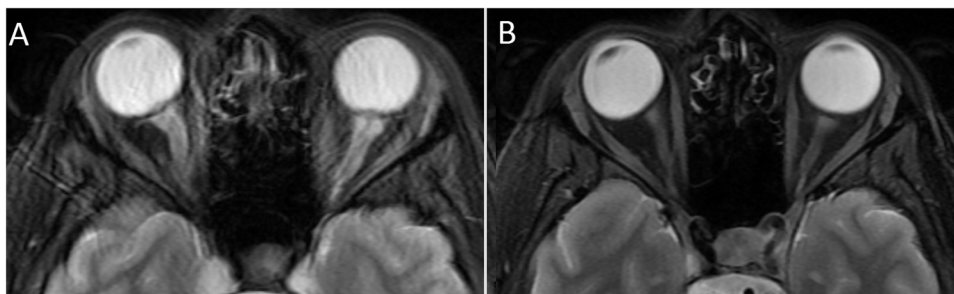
A) Pre-decompression axial T2 MR image over the orbits demonstrates prominence of the optic nerve sheath complex near the heads of the optic nerves. B) Post-ventriculoperitoneal shunting axial T2 MR image over the orbits demonstrates a return to normal with the optic nerve sheath complex now uniform in diameter along its length with significantly less T2 hyperintense cerebral spinal fluid tracking along the optic nerves.
